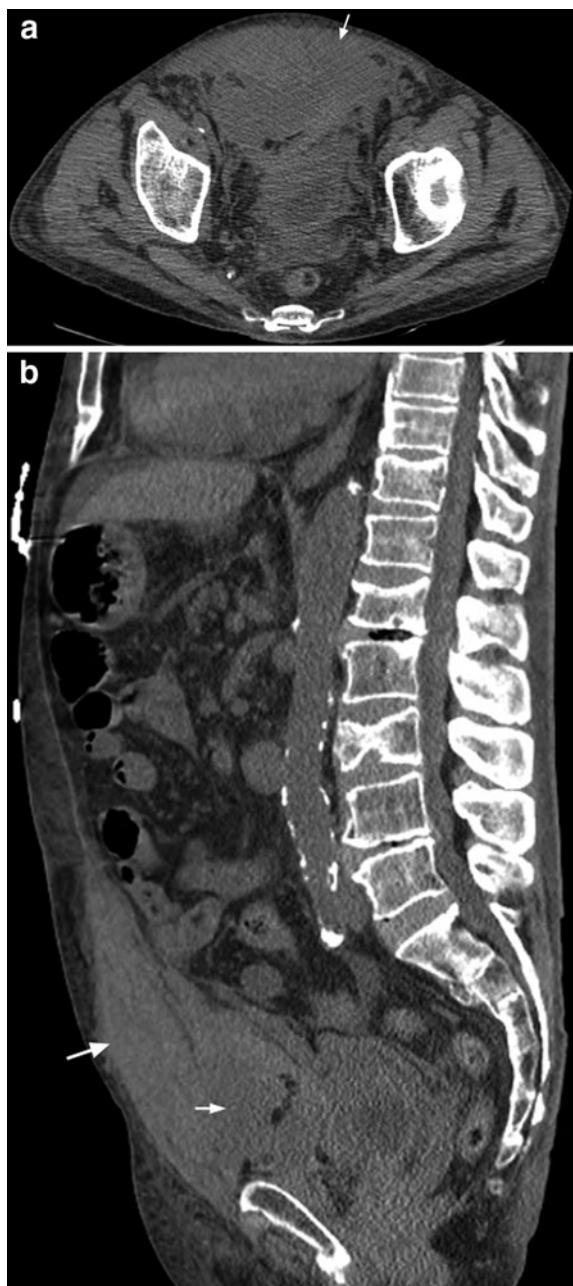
Rectus sheath hematoma in a hemodialysis patient. a The axial unenhanced CT scan of the abdomen shows a hematoma of the rectus (arrow). b The sagittal reformatted CT image of the abdomen more clearly shows the hematoma developed below the level of the arcuate line and breaks back through the fascia transversalis into the Retzius space (thin arrow)
